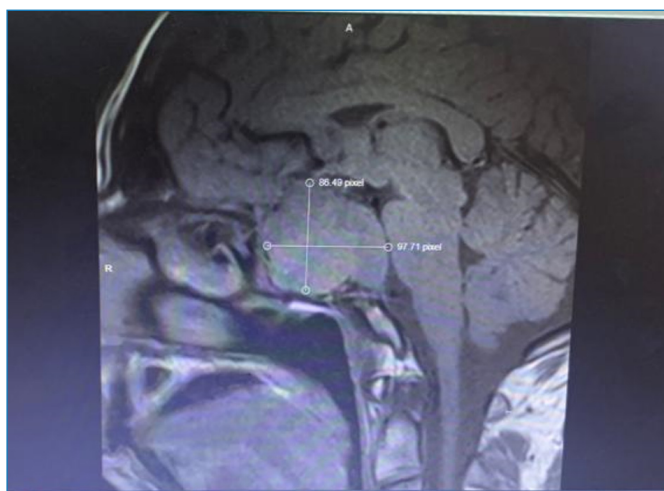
MRI image of the patient's pituitary adenoma
